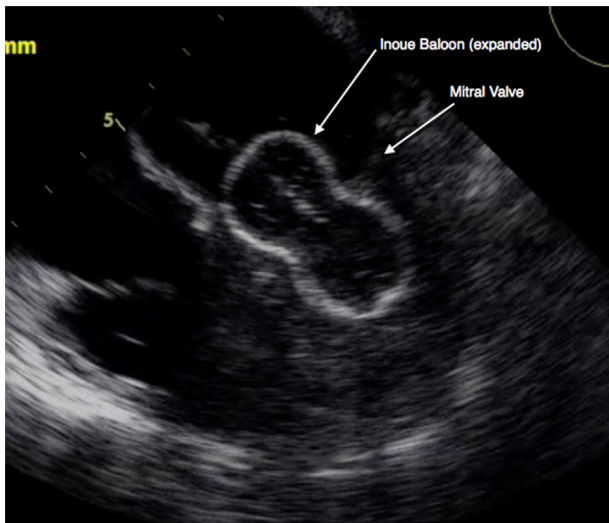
Transesophageal echocardiography image of the Inoue balloon expanded across a stenotic mitral valve.
